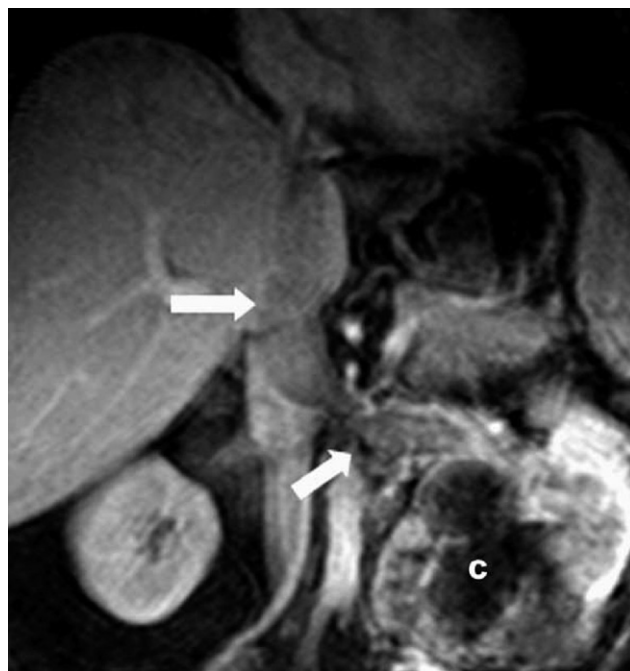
Clear cell RCC with characteristic angio-invasion. Coronal, gadolinium-enhanced T1-weighted MRI shows a large clear cell RCC (C) arising from the left kidney with associated tumor thrombus that extends into the left renal vein and the IVC (arrows).
